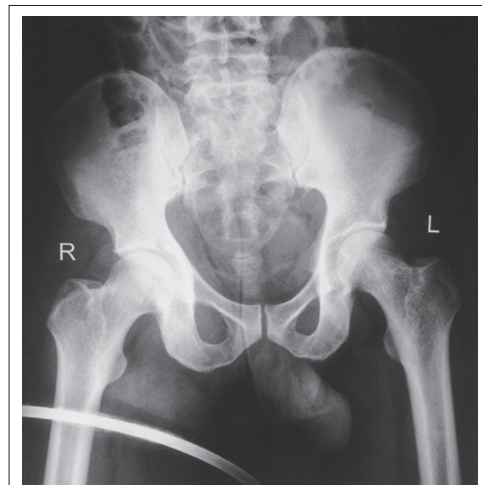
Check X-ray confirming reduction of hip joint.
